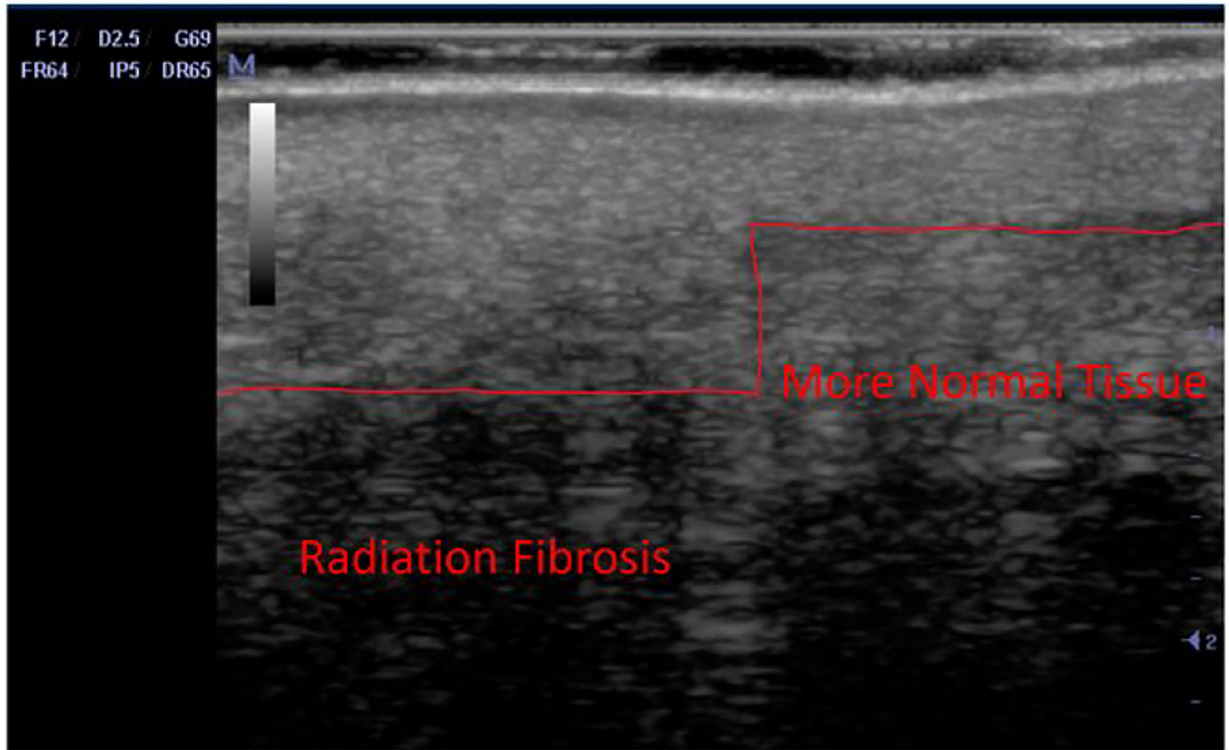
Ultrasound image showing radiation fibrosis on patient D's back.
